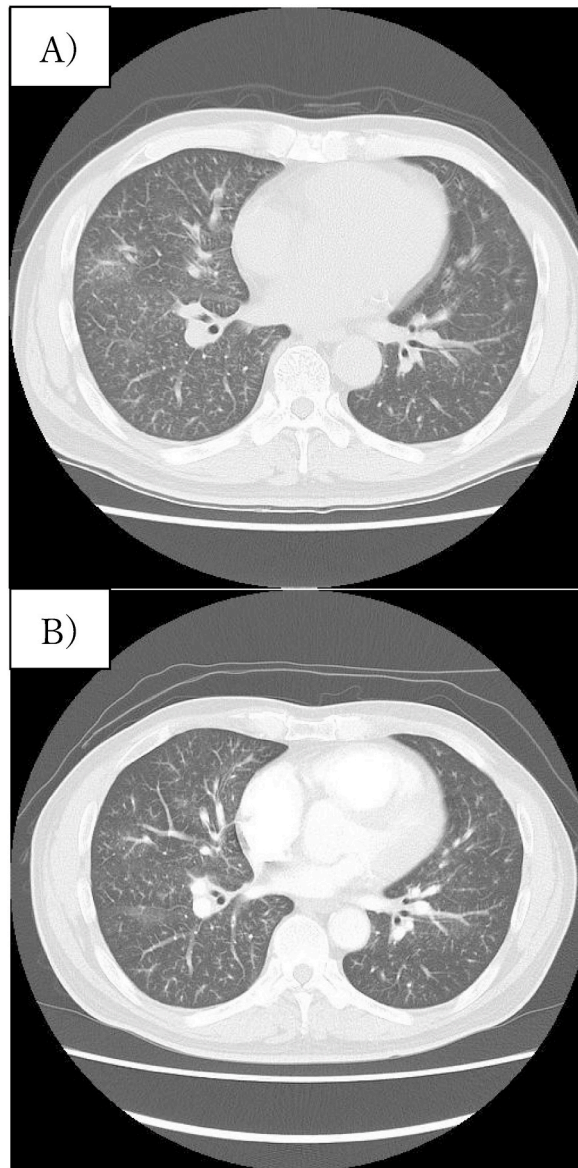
(A) Chest high-resolution CT (HRCT) on the first day shows thickening of the broncho-vascular bundle, tree-in-bud appearance, and interlobular septal thickening.
